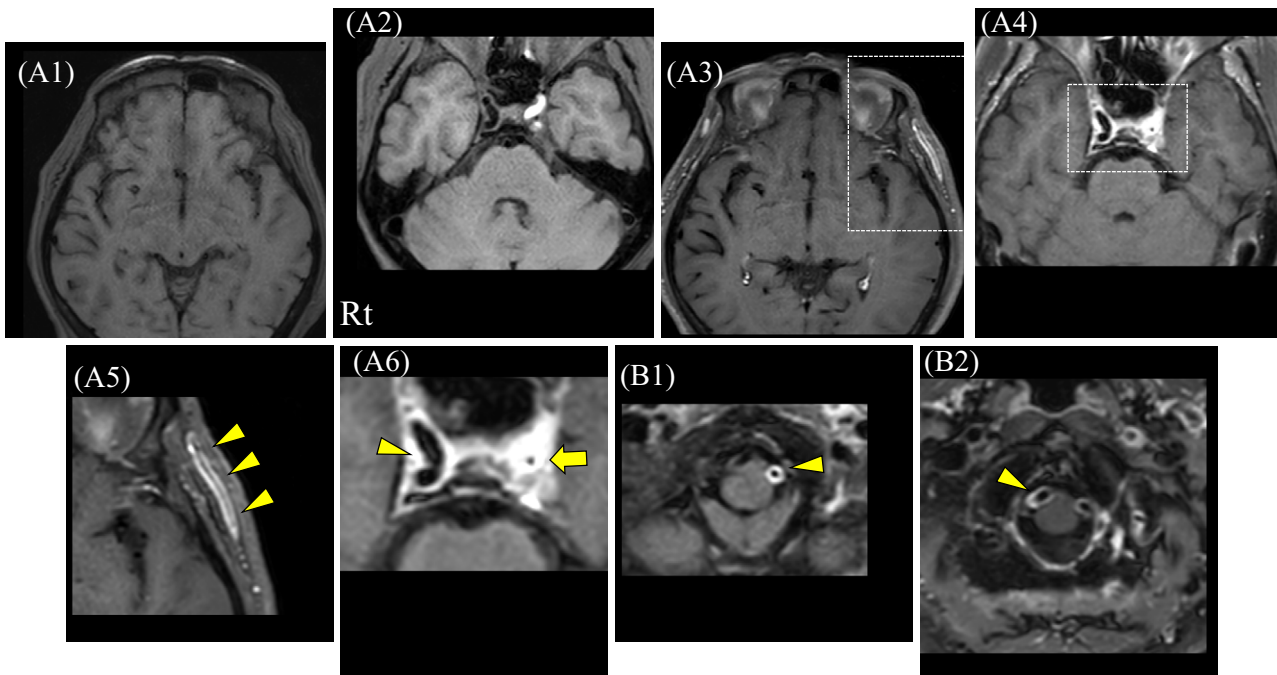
Plain and contrast-enhanced MRI of the brain (axial CE-MSDE-3D TSE) performed after admission. (A1, 2) MSDE-3D TSE depicts the walls of the left temporal artery and ICAs with iso-intensity signals. (A3, 4) Vessel wall enhancement (VWE) is observed in the walls of the left temporal artery and ICAs on CE-MSDE-3D TSE. (A5, 6) Magnified images of the areas enclosed by dotted lines in A3, 4 show the enhanced artery walls of the left temporal artery (arrowheads) and ICAs (right: arrowhead, left: arrow). (B1, 2) The vertebral arteries are also bilaterally enhanced (arrowheads). MSDE-3D TSE: motion-sensitized driven equilibrium three-dimensional turbo spin echo sequence, CE-MSDE-3D TSE: contrast-enhanced three-dimensional turbo spin echo sequence
